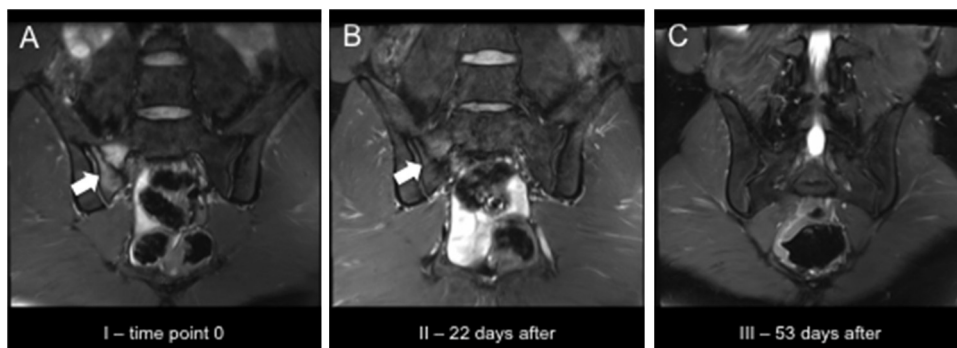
Bone marrow oedema of the os sacrum. MR-imaging of a 25-year-old high-professional female tennis player playing at the highest international level demonstrates a bone marrow oedema with a stress fracture of the right os sacrum. The athlete was unable to train and started complaining about pain after a sudden jump on her right leg 168 days before first visit in our centre. The first T2-weighted image (a frontal plane) reveals a fracture line as well as an intense adjacent bone marrow oedema within the os sacrum (arrow). Follow-up MRI 22 days later (B) after high dose vitamin D and bisphosphonate treatment show already a significant decrease of the oedema and reduced fracture line (arrow). Consecutive MR-imaging one month later (C; the athlete was meanwhile pain-free) reveals an almost complete resorption of the oedema. The fracture line is not detectable anymore. The athlete was back to full unrestricted tennis training (RTC) within 98 days after correct diagnosis and beginning of adequate treatment.
